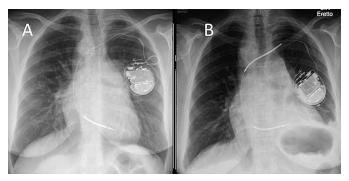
X-ray prior and after transvenous lead extraction showing a newly elevated leftsided hemidaphragm.
